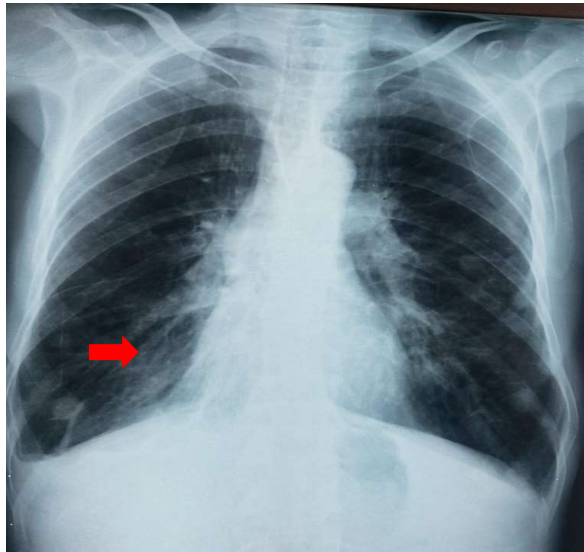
Frontal chest X-ray: right basithoracic atelectasis (red arrow)
